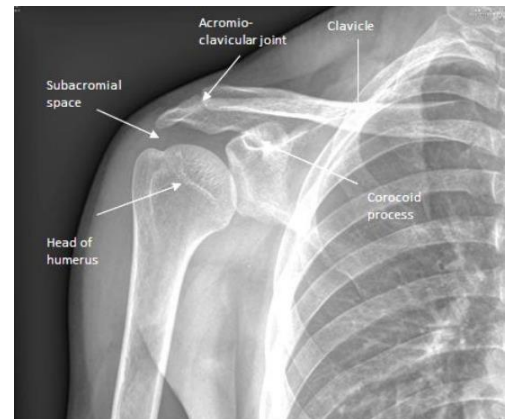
Plain radiograph of shoulder.
